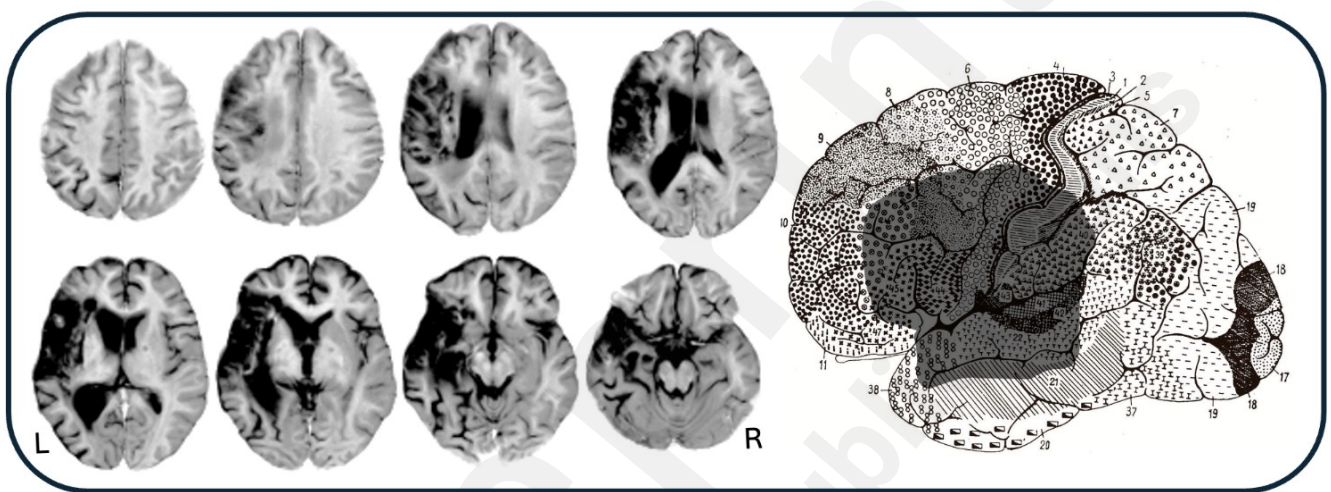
Axial brain MRI scans highlight an extensive neuroanatomical disruption affecting the left opercular region of the patient. The figure shows MRI scans performed 18 months from the cerebrovascular accident. The first image series from left to right shows progressive slices of the brain at different levels from top to bottom. The localization and extent of the lesion was depicted on the left hemisphere with reference to Broadman's map areas. The most posterior part of the superior and middle temporal gyri was partially spared as well as the angular gyrus and part of the supramarginal gyrus.
